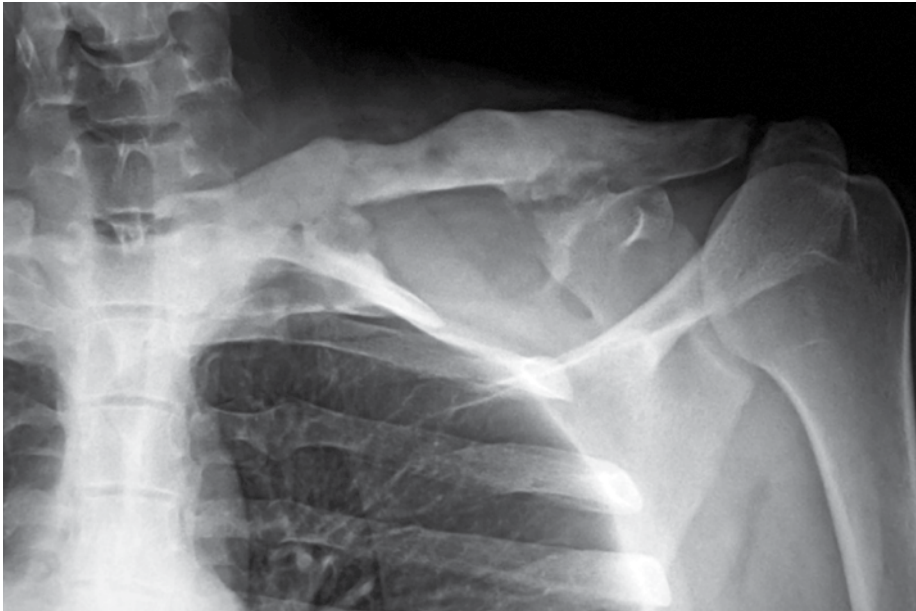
Plain X-ray showing abnormal left clavicle with expansion of this bone and large sclerotic area
